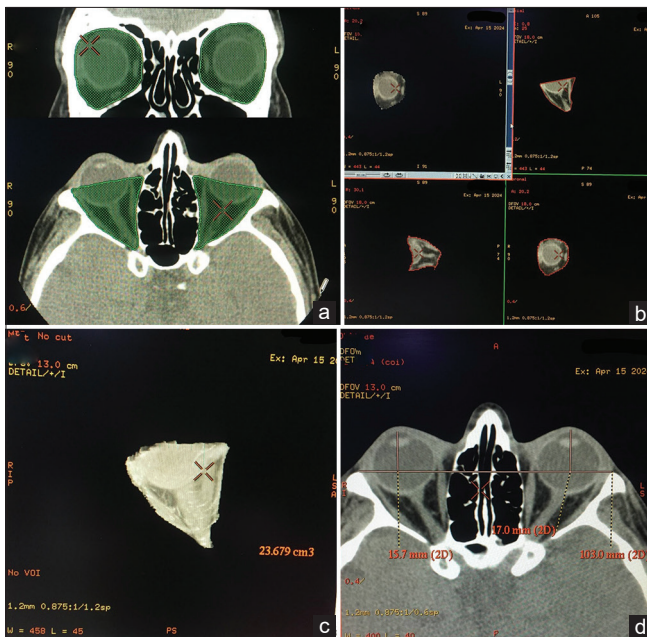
Orbital volume and radiographic enophthalmos (RE) measurement (a) we identified orbital boundaries and outlined the enclosed orbital area in each slice, in AW VolumeShare 2 software (b) the software calculated the orbital volume by summation of all outlined sections (c) the software regenerated the final reconstructed 3D orbital image and showed the orbital volume (d) RE measurement was performed by lining the anterior parts of two zygomatic bones in the section containing corneal apex. The vertical line from the corneal apex to this line was drawn, and the difference between the two sides reveals RE
